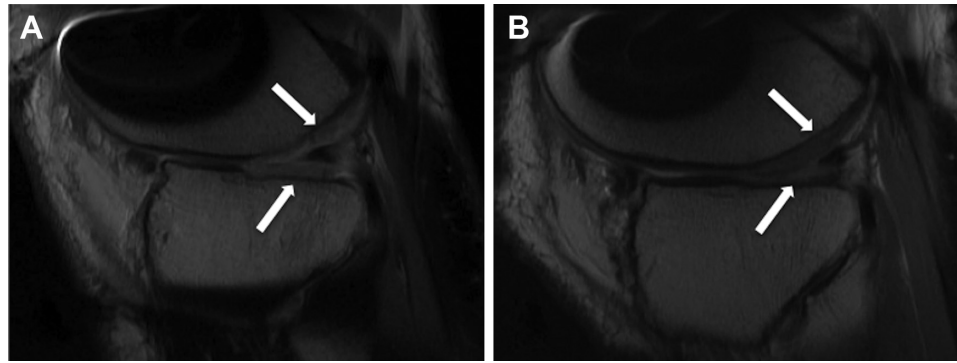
Postoperative sagittal magnetic resonance imaging (proton density fat saturated) of the involved compartment. This patient's previous surgical procedures included microfracture, drilling to the lateral femoral condyle (LFC), and removal of a loose body. Autologous chondrocyte implantation (ACI) to the LFC, lateral tibial plateau (LTP), and trochlea (lesion sizes: 600 mm², 225 mm², and 225 mm², respectively) was performed with concomitant distal femoral osteotomy and tibial tubercle osteotomy. (A) Four months after ACI, the implantation site is completely covered by tissue that shows intermediate to high signal in the LFC and LTP (arrows). (B) One year after ACI, the implantation site is completely covered by tissue that shows more homogeneity in signal intensity with a congruent articular surface (arrows). No subjacent marrow edema is detected.
